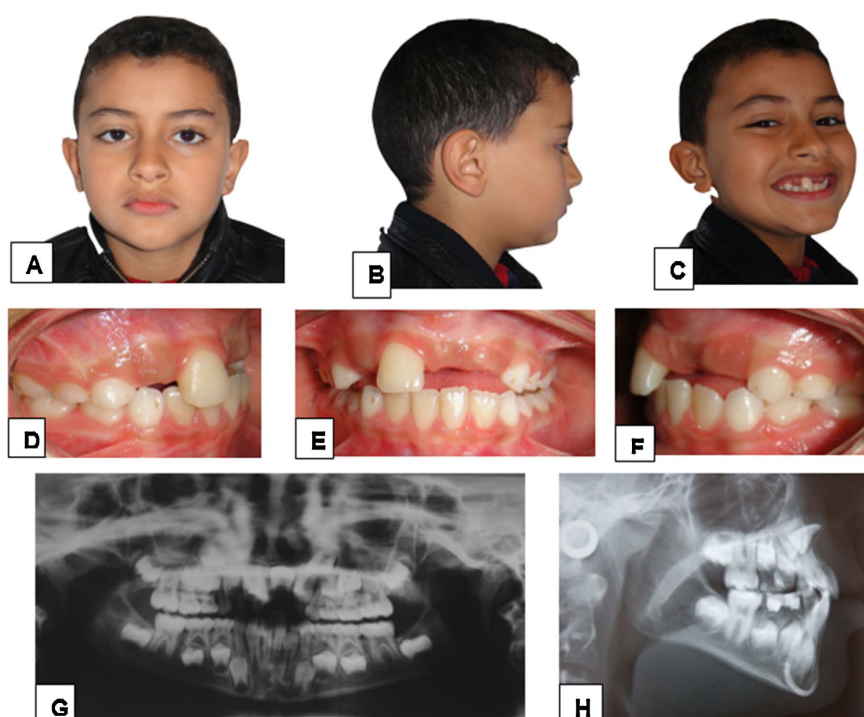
Pre-treatment document (8-year-old patient). Extraoral photographs: front view (A), profile view (B), three-quarter smile view (C); intraoral photographs: right lateral occlusion view (D), front occlusion view (E), left lateral occlusion view (F). Panoramic radiograph of a patient with permanent left dilaceration (G), lateral cephalogram of an 8-year-old patient (H).
